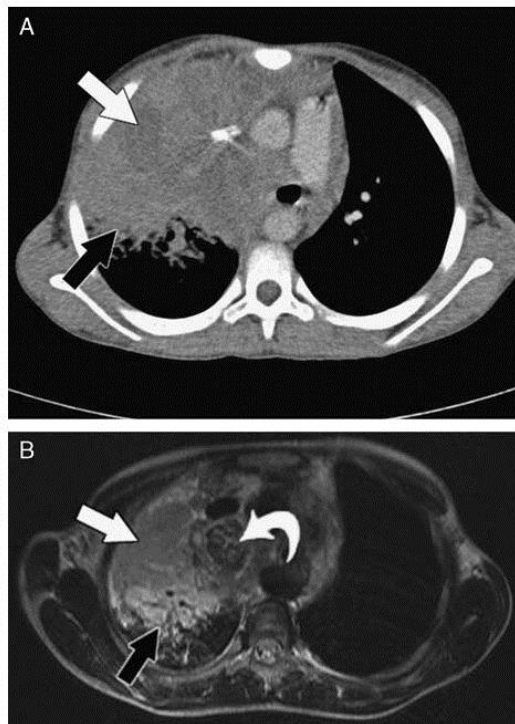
Axial images demonstrating airspace consolidation and lung necrosis on CT and STIR MRI. A, Postcontrast CT scan of the lung demonstrates a necrotic area of low density lacking enhancement and air bronchograms (white arrow), located centrally in an area of airspace consolidation (black arrow). B, STIR MRI demonstrates low signal intensity (white arrow) corresponding to the area of necrosis on CT. Also demonstrated are paratracheal lymphadenopathy (curved arrow) of even lower signal intensity and enhancing airspace disease with air bronchograms (black arrow), indicating consolidation without necrosis.
